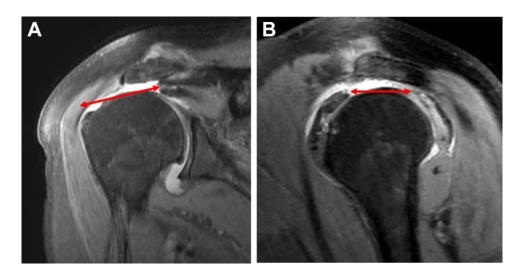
Tear size measurement on T2-weighted image (double-sided red arrows). (A) Coronal tear size on coronal oblique image. (B) Sagittal tear size on sagittal oblique image.
